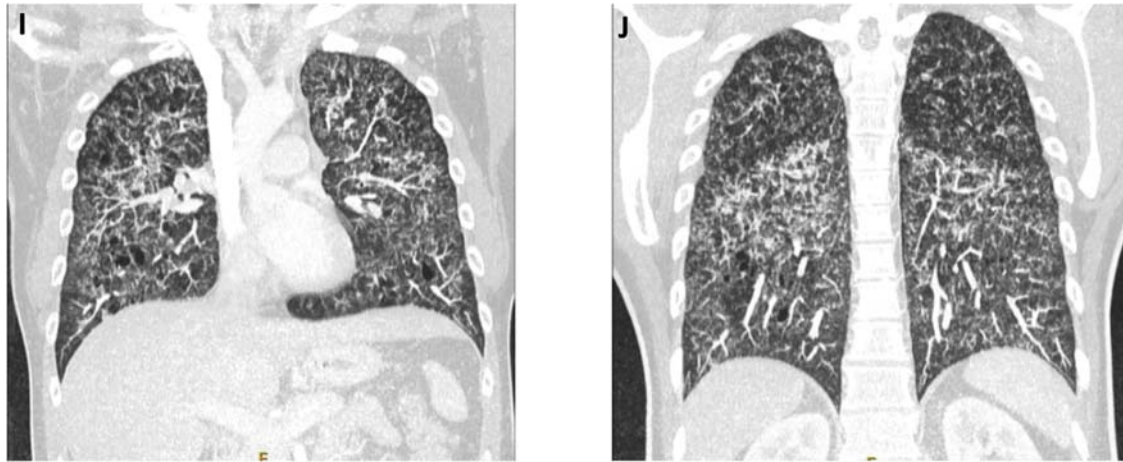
Findings from HRCT at the time of consensus diagnosis of PLCH. Overall showing multiple bilateral innumerable and irregularly bizarre-shaped cysts with varying wall thickness. Ground glass opacities and reticulonodular patterns. Upper to middle zone involvement is more significant, no involvement of costophrenic angles. Multiple lymph nodes seen along the perivascular, paratracheal and hilar regions. Enlarged lymph nodes predominantly at the hilar and subcarinal region. A-D: Axial scan of upper to middle zone. E-H: Axial scan of middle to lower zone. I-J: Coronal scan.
